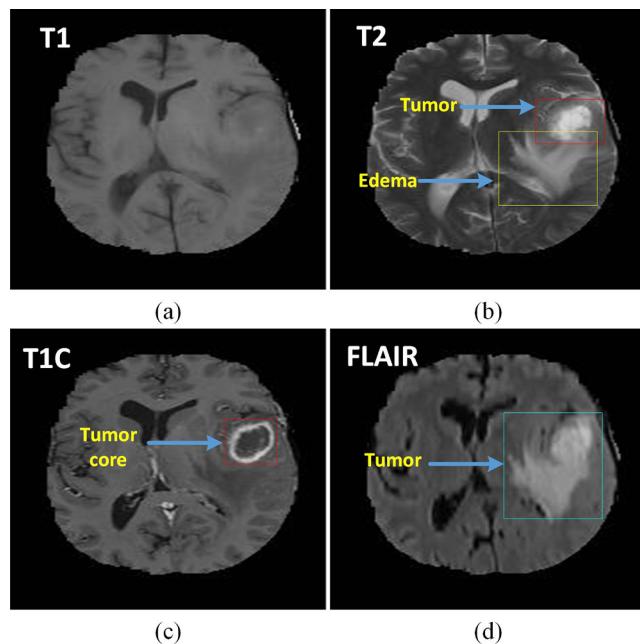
Multi-parametric MR scans of brain modalities showing a) T1, b) T2, c) T1C (T1 Contrast-enhanced) and d) Fluid attenuated inversion recovery (FLAIR).
